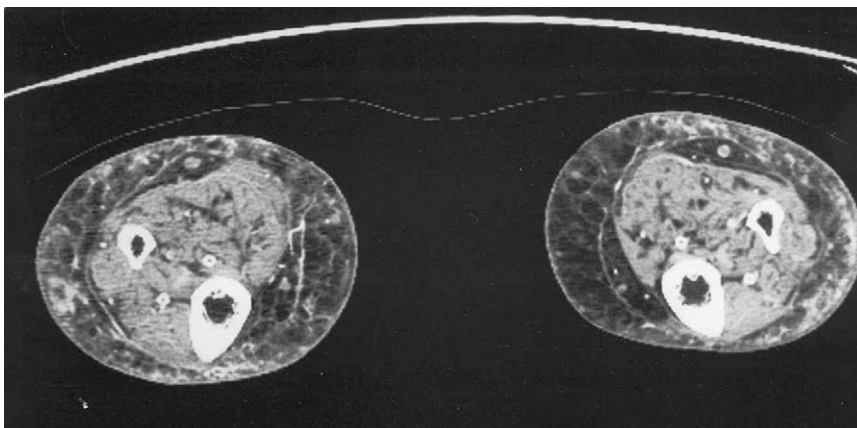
Computed tomography of the lower extremities demonstrating with soft tissue calcification.
